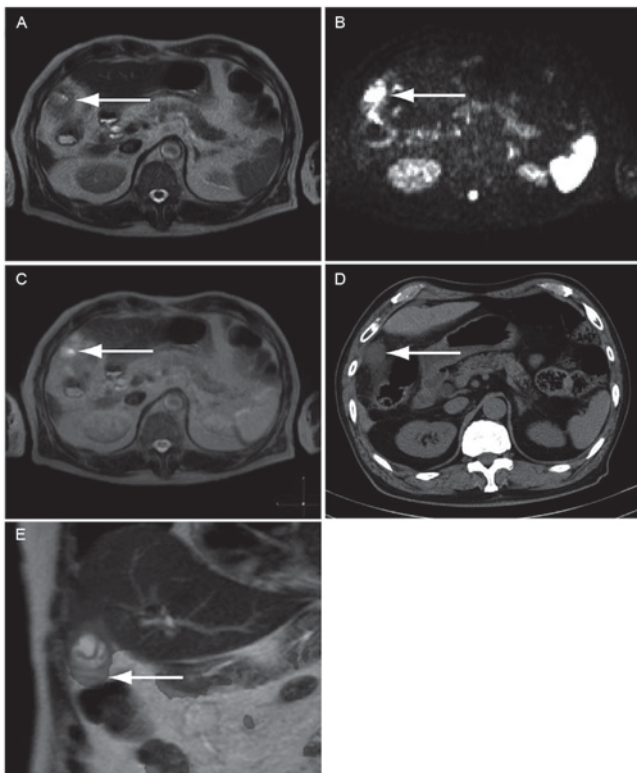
Pericholecystic inflammation. An 86-year-old man presented with upper abdominal pain. (A) T2-weighted imaging revealed a pericholecystic space. (B) DWIBS showed an area of high signal intensity in the pericholecystic space. (C) Anatomical analysis of the area of high signal intensity was conducted using DWIBS/T2. (D) Computed tomography images contained a low-density area in the pericholecystic space. (E) A cross section of DWIBS/T2 revealed pericholecystic inflammation. Arrows indicate the area of pericholecystic inflammation. All the figures were representative of the participants in the present study. DWIBS, diffusion-weighted whole body imaging with background body signal suppression; DWIBS/T2, DWIBS and T2 image fusion.
